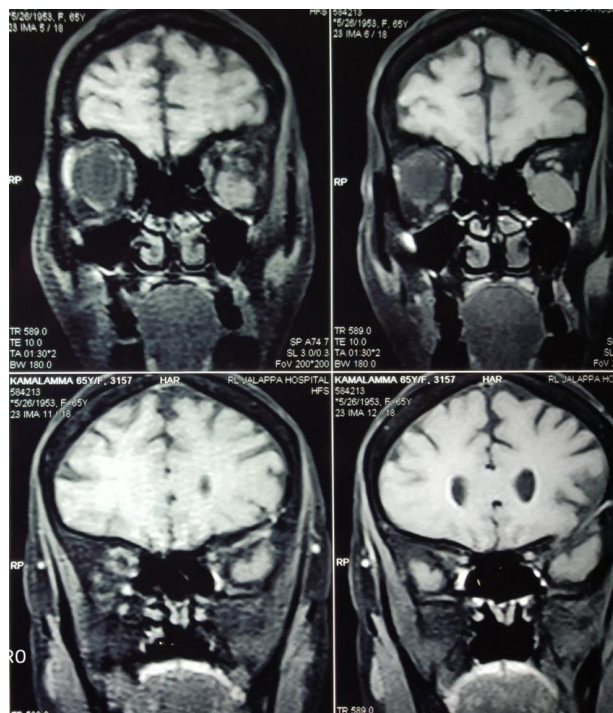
MRI shows well-defined 1.8×1.8×1.7 cm enhancing lobulated solid left intraorbital mass extending along the inferior aspect of left optic nerve with mass effect (stretching and lifting) on optic nerve.
